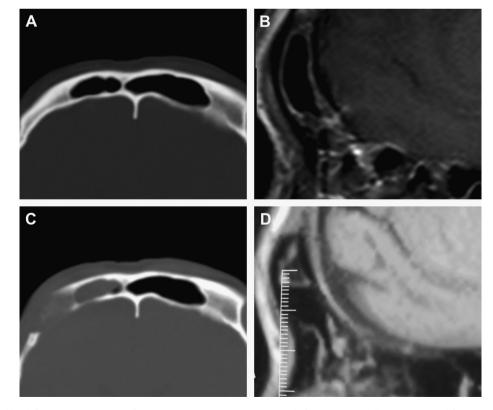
A patient with Rathke cleft cysts underwent transfrontal craniotomy. A, intact FS, CT scan before surgery (axial). B, intact FS and frontonasal duct, MRI before surgery (sagittal). C, the FS opening was sealed with gelfoam saturated with EC glue; CT scan, 2 months after surgery (axial). D, the functional mucosal layer was reconstructed to restore mini-FS physiological function, 3 years after surgery (sagittal MRI). CT, computed tomography; EC glue, medical aural and encephalic glue; FS, frontal sinus; MRI, magnetic resonance imaging.
